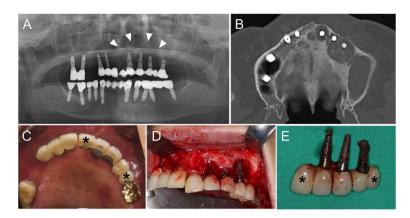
Representative case of peri-implant medication-related osteonecrosis of the jaw (PI-MRONJ) associated with a prosthesis featuring cantilever extension. (A) preoperative panoramic radiograph (arrowheads, PI-MRONJ affected area), (B) preoperative computed tomography image, (C) preoperative clinical photograph (asterisk, cantilever extension), (D) intraoperative photograph, (E) removed prosthesis (asterisk, cantilever extension).
